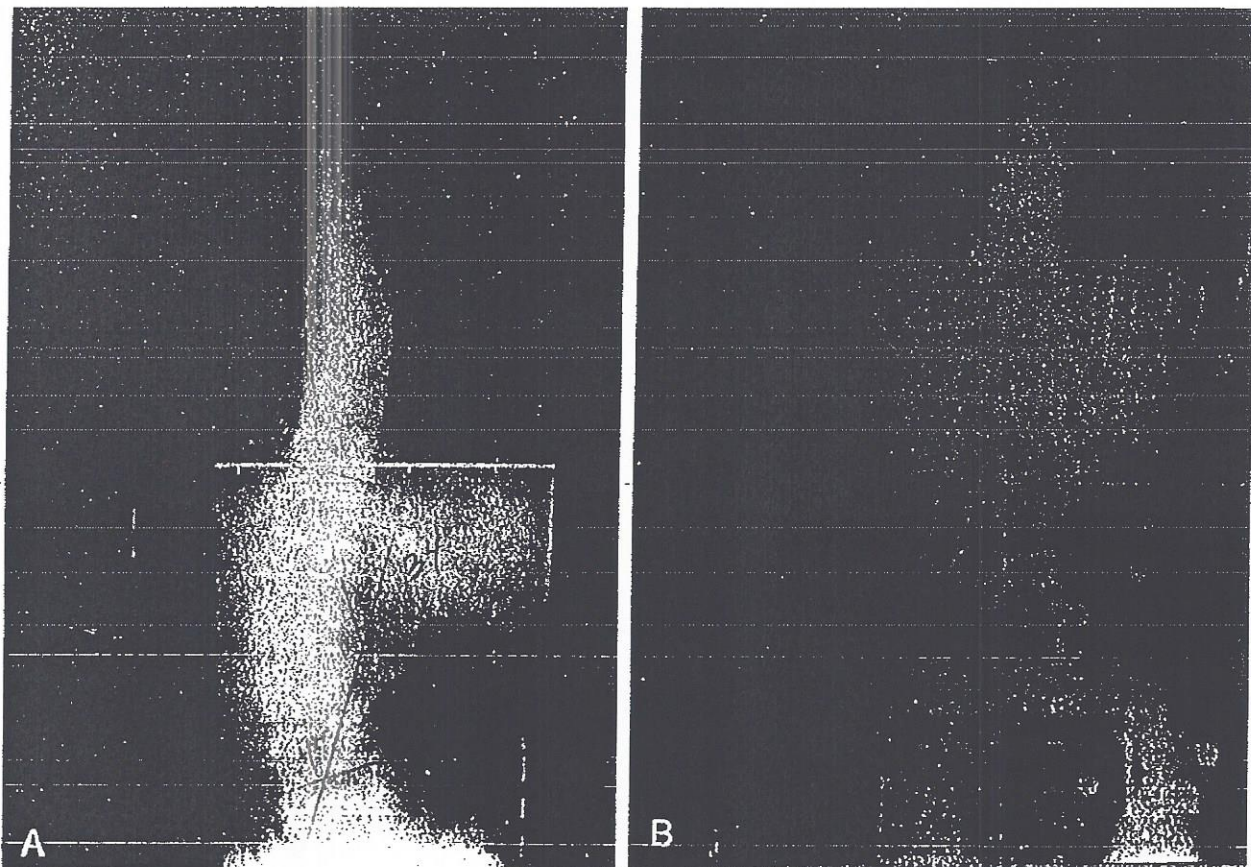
Double curves can be corrected in the brace: A, A 10-year, 9-month-old girl with double major scoliosis prior to bracing. B, Radiograph obtained in Charleston bending brace showing significant correction of both curvatures.
